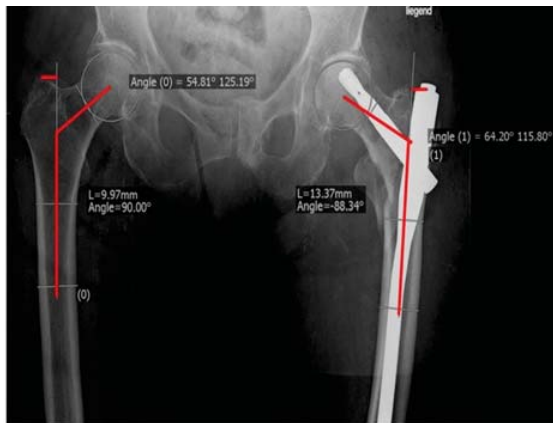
Neck shaft angle in the immediate postoperative pelvis with bilateral hip radiographs
